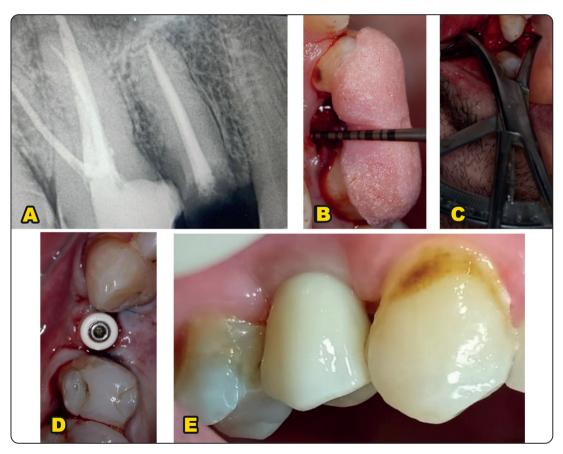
(A to E) is showing A) Preoperative x-ray of upper right first premolar B) Mid-palatal crestal height measured by periodontal probe C) Ridge Mapping Caliper (Bucco palatal (width D) implant placement after osteotomy site preparation and placement of healing abutment E) crown delivery into patient mouth
